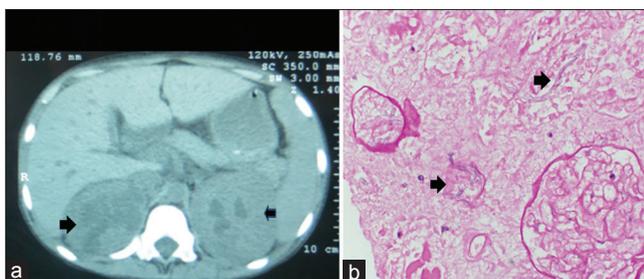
(a) Computed tomography abdomen showing hypodensities in both kidneys (b) postmortem renal biopsy showing aseptate fungal hyphae with acute angle branching (Case 1)
